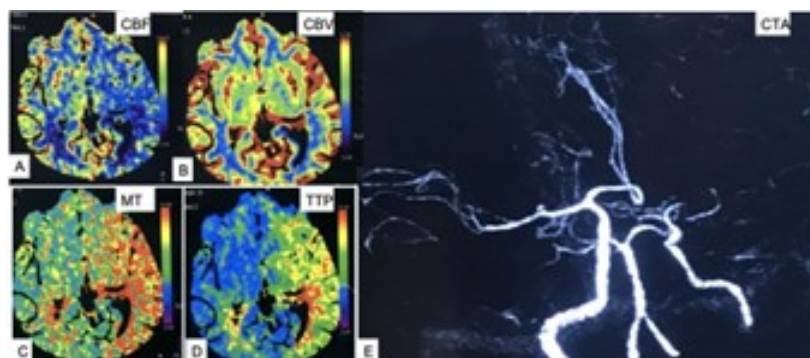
(A–D) Perfusion CT scan of the brain in a patient with left MCA occlusion (E), showing left MCA territory hypoperfusion. Source: Figure by authors.
